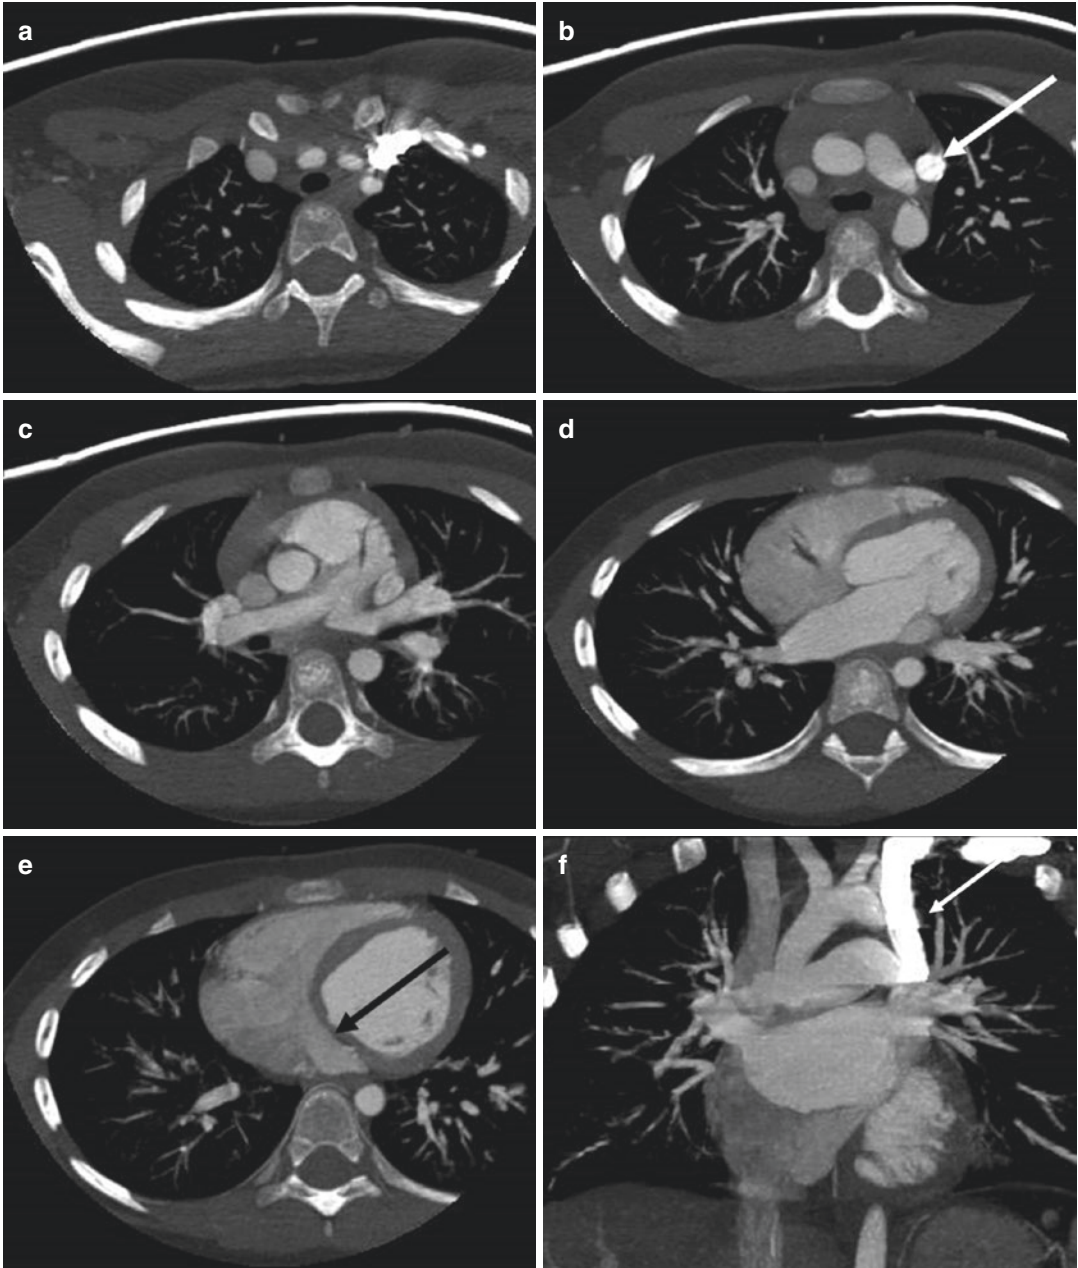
Persistent left superior vena cava at CT angiography. (a)–(e) Axial thin maximum intensity projection (MIP), (f) coronal MIP, and (g) sagittal oblique MIP images demonstrate a persistent left superior vena cava
